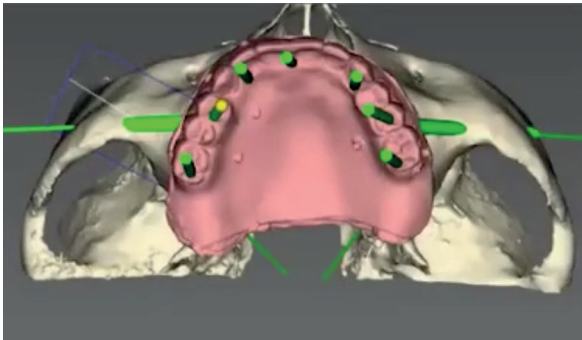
CT file and prosthetic project data transfer.
